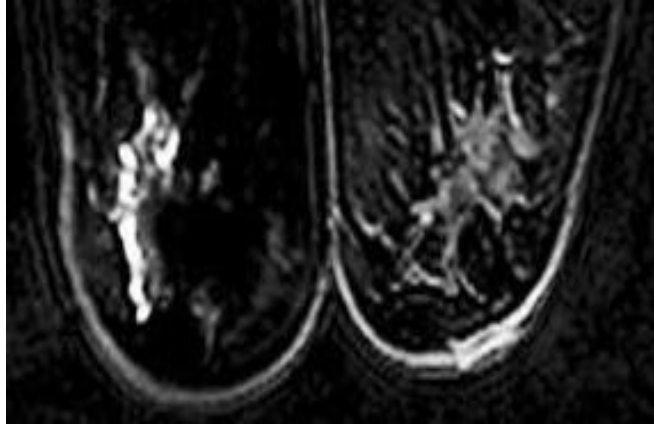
Lobular Carcinoma in Situ LCIS in contrast enhancement in MRI
